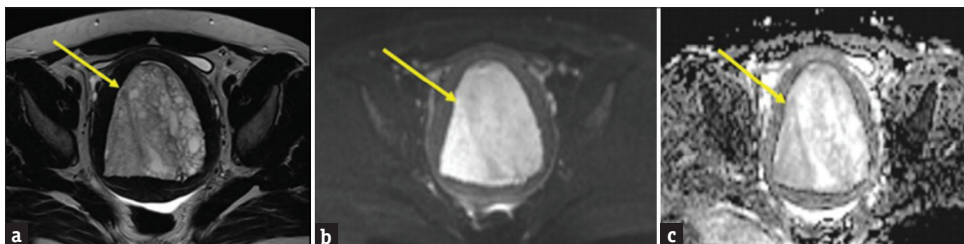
Endometrial hyperplasia in a 45-year-old female with: (a) Axial T2-weighted image demonstrating markedly distended endometrial cavity with smooth compressed junctional zone all around, internal morphology is smooth marginated Sol with multiple cysts of varying sizes showing predominant high T2 signal. (b) High b-value (b = 800) diffusion-weighted image shows high SI and (c) apparent diffusion coefficient map shows high SI (arrow) with values 1.7–2.1, which indicates no diffusion restriction
